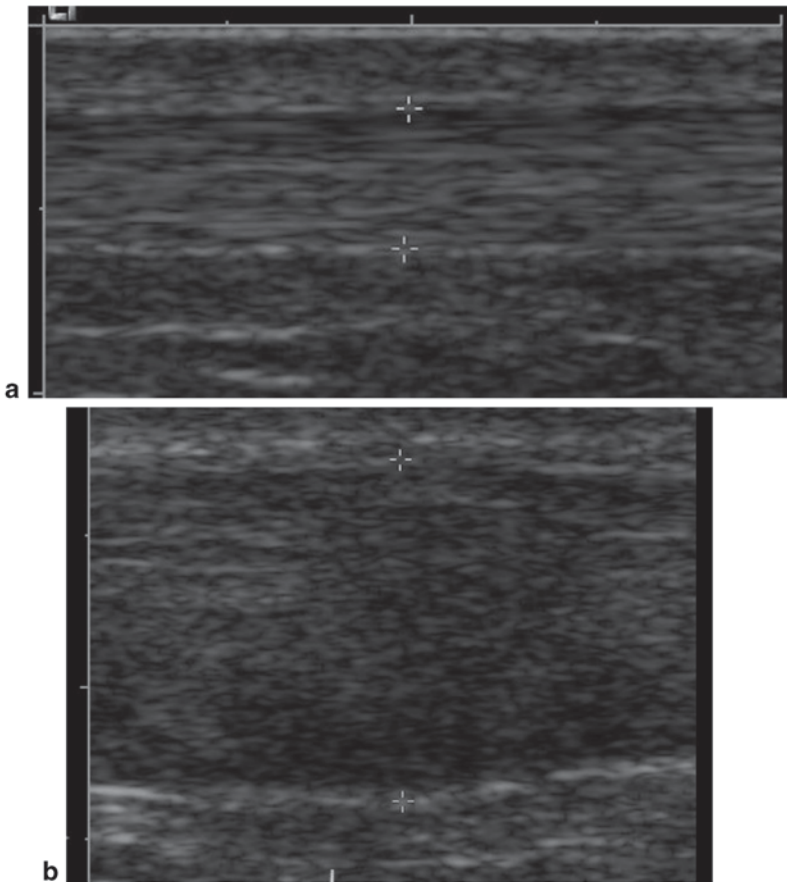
Achilles tendon sonographic longitudinal images. a normal. b presence of tendon xanthoma. Calipers are located in the proximal and distal borders of the Achilles tendons
